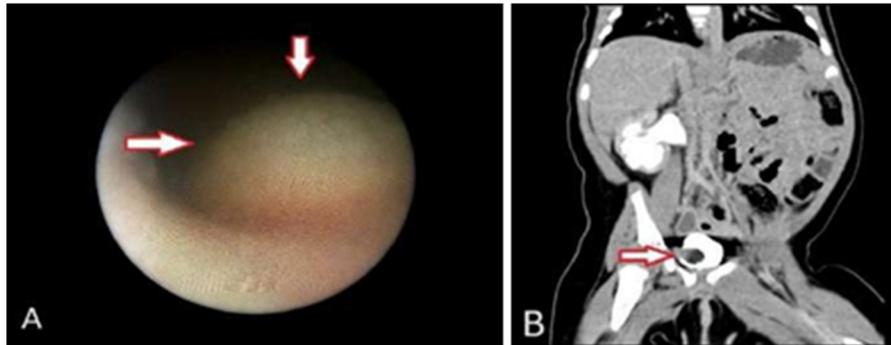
Ureterocele. A: cystoscopic image; B: uro-CT
